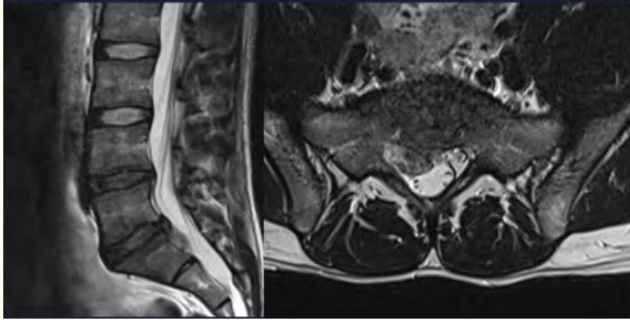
MRI showing left extrude LDH l4-l5 with lower migration.
